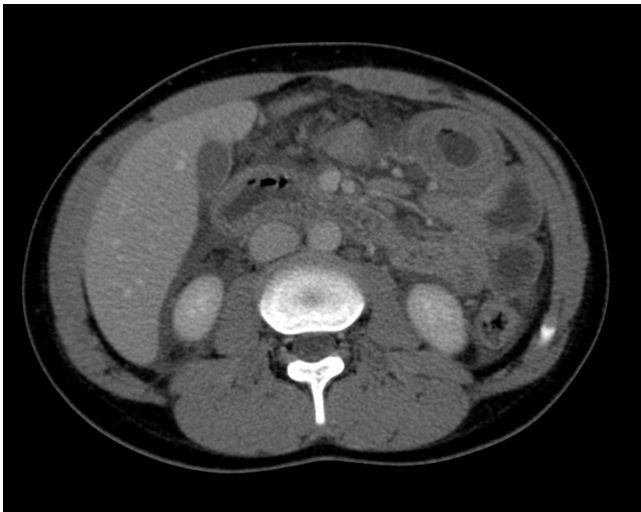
Computed tomography scan showing bowel wall edema.
